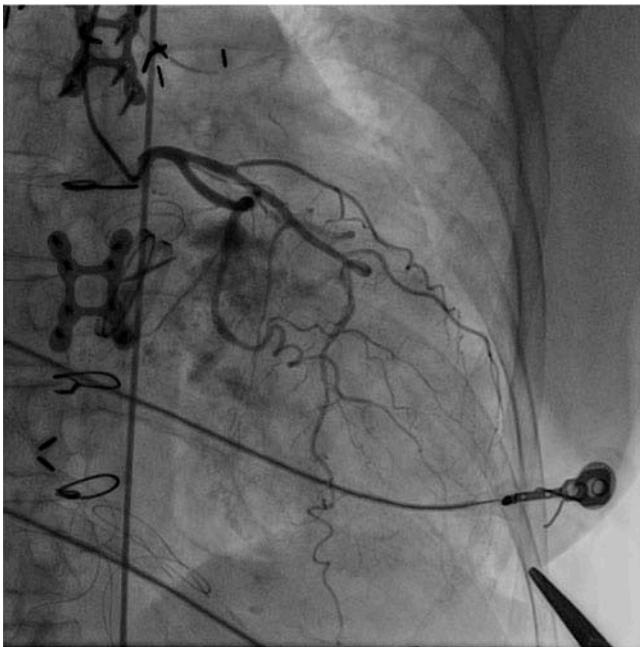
Coronary angiography prior to transapical puncture. Once the apex is identified by palpation and transthoracic echocardiography, a marker (hemostat) is placed over the LV apex and coronary angiography is performed. If the course of the left anterior descending artery is adequately distant from the marker, it is safe to proceed with percutaneous transapical puncture.
